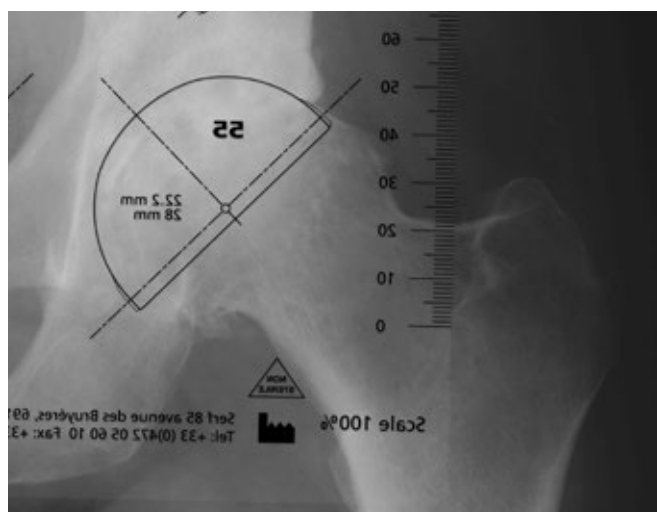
Properly positioned acetabular x-ray template
